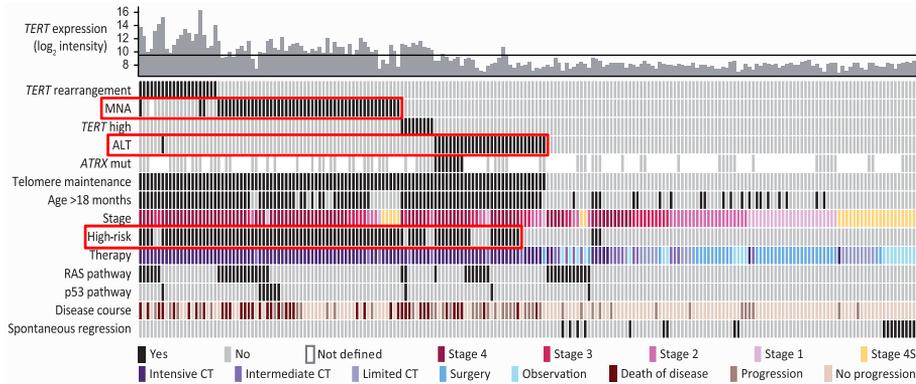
Clinical and molecular characteristics across 208 untreated neuroblastoma cases, displayed in left-to-right order. Red boxes highlight MNA, ALT, and high-risk cases, while the black line in the top panel indicates the TERT expression threshold. CT, chemotherapy; MNA, MYCN amplification. Adapted from Ackermann et al., *Science*, 2018, with permission from AAAS²¹.
